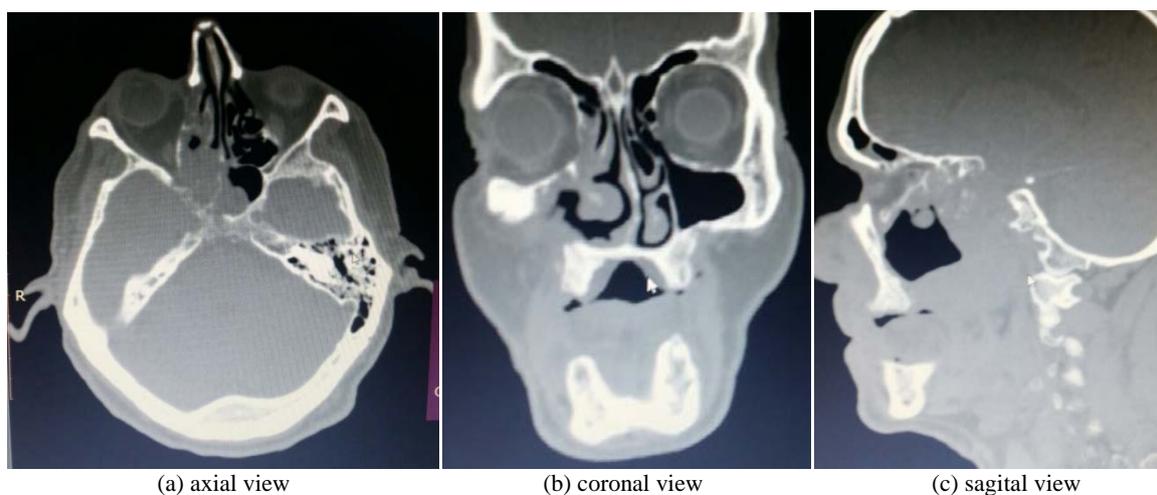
Computed tomography of the head.
